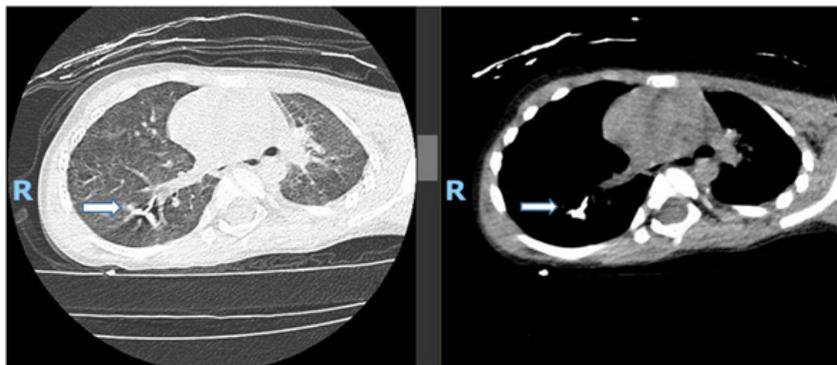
CT scan chest (horizontal view) showed: Metallic foreign body at the bronchioles of the right lower zone measured 2.5cm.
